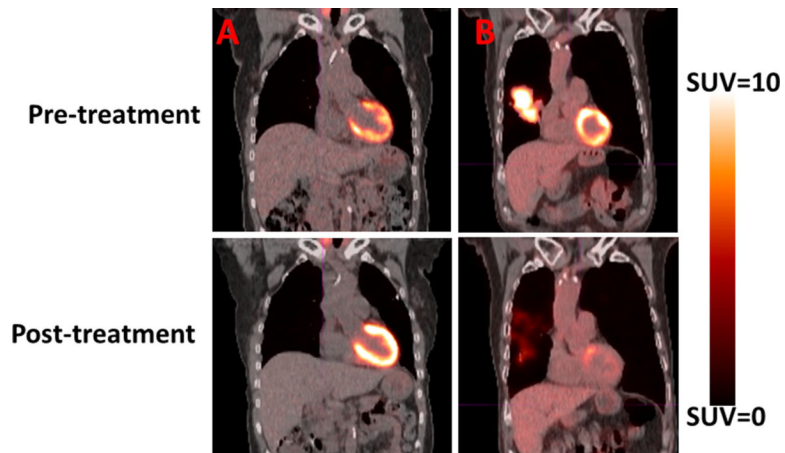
Pretreatment and posttreatment positron emission tomography/computed tomography scans are shown for 2 patients. (A) The patient presented displayed an increase in posttreatment cardiac standardized uptake values (SUV) compared with pretreatment cardiac SUV. (B) Demonstrated a decrease in posttreatment cardiac SUV compared with pretreatment cardiac SUV.
